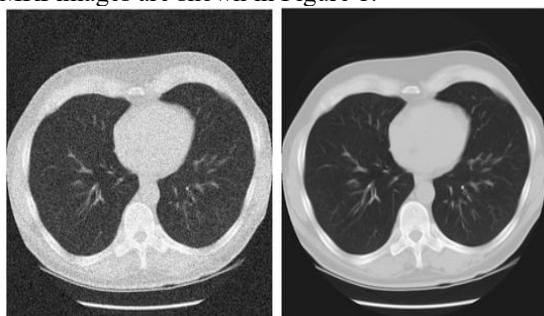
Noisy and Denoised Lung MRI Image
